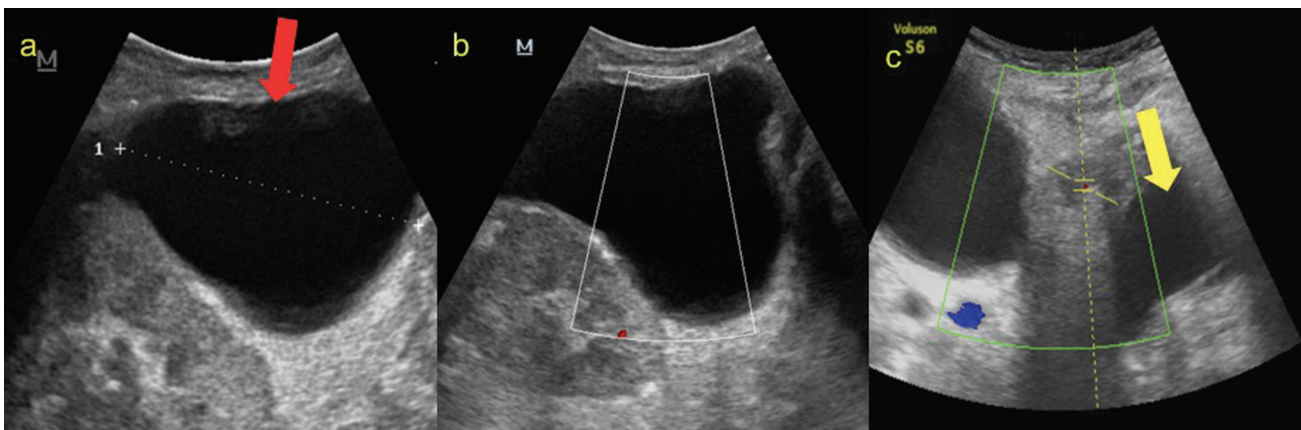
Ultrasound images of a 53-year-old female patient (3 weeks postrenal transplantation) show thin-walled anechoic collection (red arrow) with no solid component/septation (a) and no significant intralesional vascularity on doppler scan (b) was noted adjacent to the transplanted kidney. (c) shows the relationship of collection to the bladder (yellow arrow) – s/o lymphocele.
